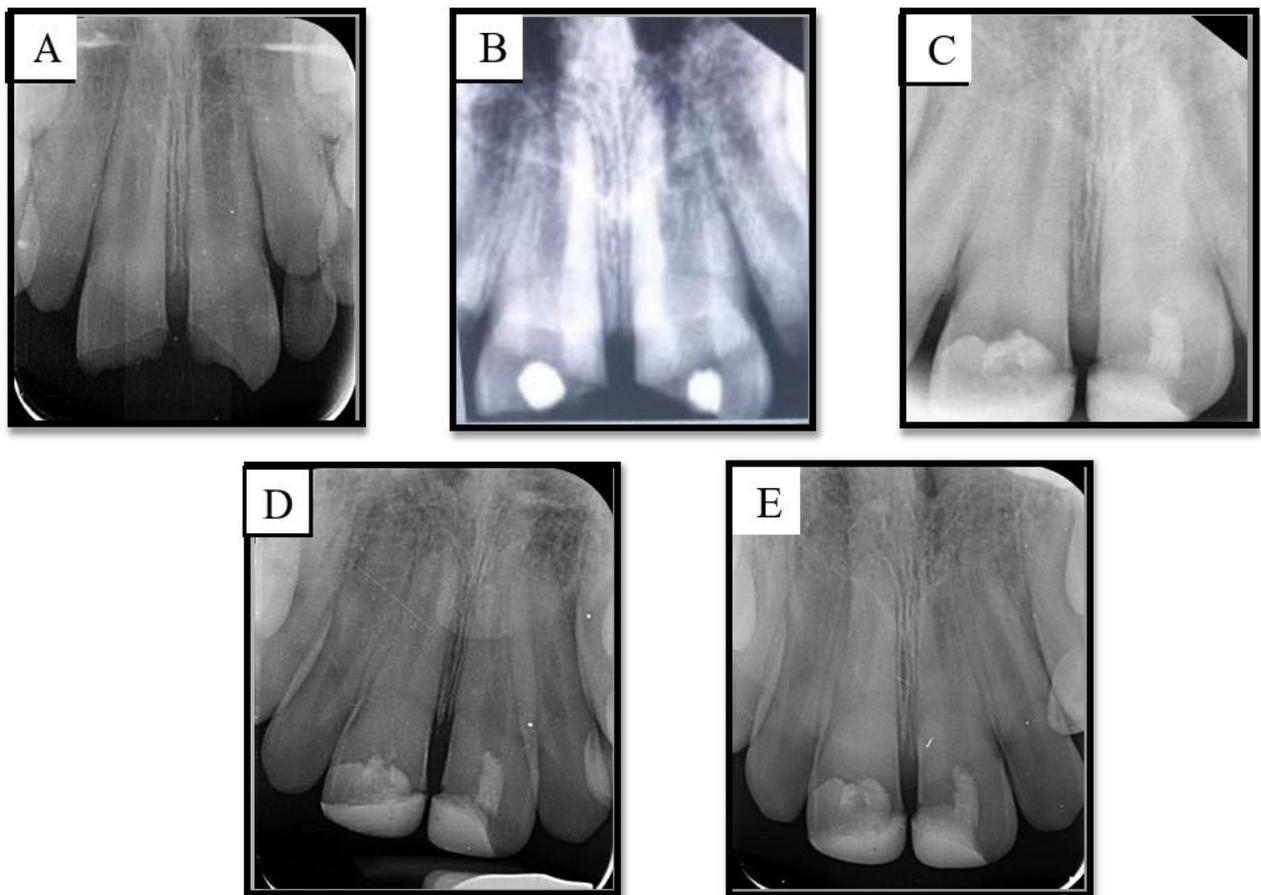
A) Preoperative radiograph depicting periapical lesion and open apices in relation to 11 and 21. B) Triple antibiotic paste was placed followed by temporary restoration. C) After 6 weeks, Revascularization with PRF was performed followed by MTA plug. D) and E) At 24 month follow up, root formation was observed
